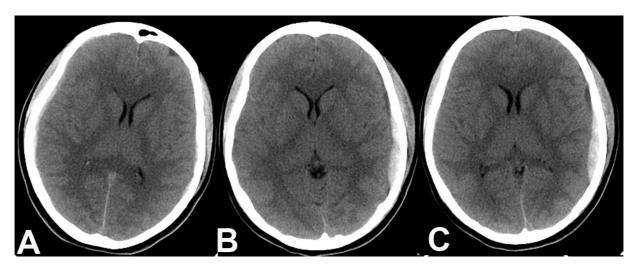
(A) Early CT scan showing thin right temporoparietal acute subdural hematoma with mild mass effect and midline shift. (B, C) Follow-up repeat CT scan after administering mannitol showing almost complete resolution of the right acute subdural hematoma and increase in the size of the left temporoparietal extradural hematoma. Also, note the mass effect due to right-sided subdural hematoma has decreased.
